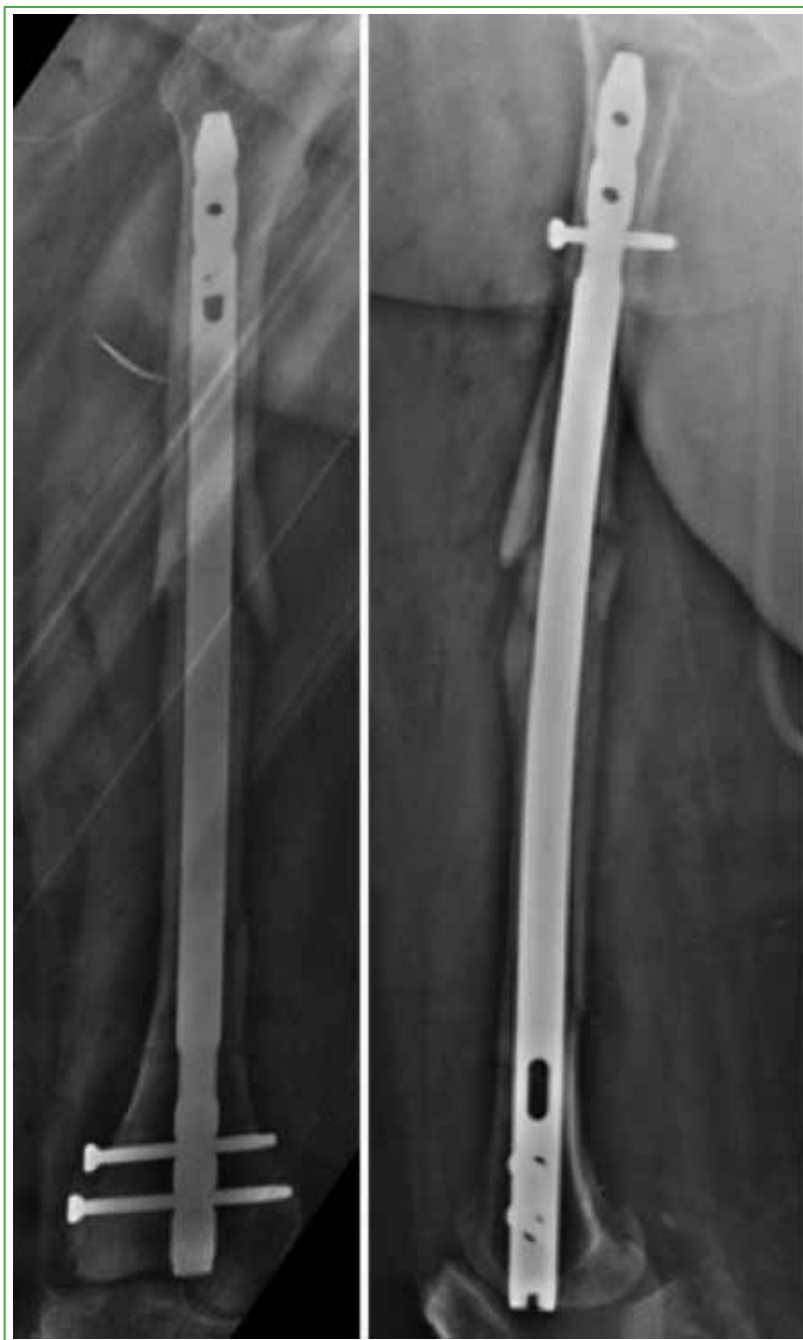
Immediate postsurgical radiographic control.
